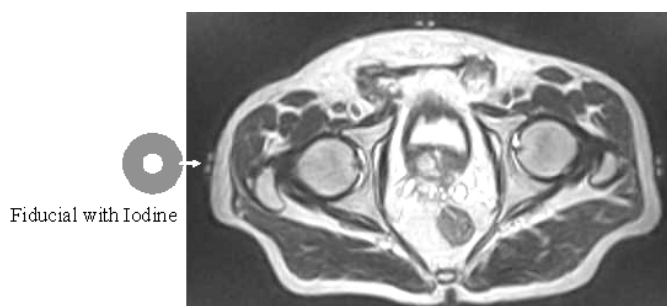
An MR image showing a special fiducial marker for MR localization. The outer diameter of the marker is 1.5 cm. The inner diameter is 4 mm. The grey part with iodine provides the MR signal. The hollow centre shows clearly on a single slice.
